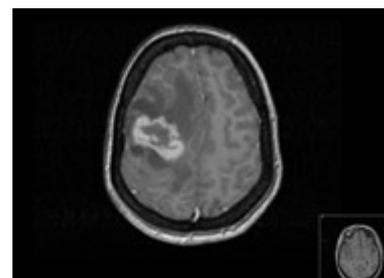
MRI head: Tuberculoma with surrounding oedema (differential diagnosis cerebral toxoplasmosis, lymphoma)
